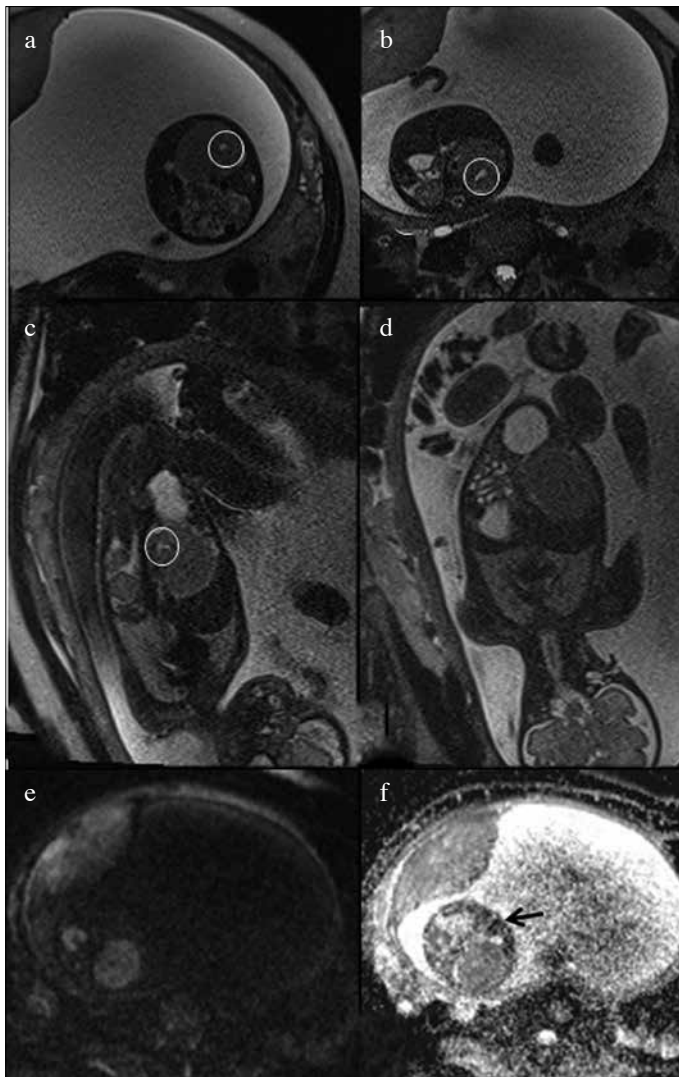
a-f. Fetal biparametric MR imaging in mesoblastic nephroma. T2-weighted images (a-d), diffusion-weighted images (e), and apparent diffusion coefficient map (f). Biparametric MR imaging shows an inhomogeneous iso-intense mass of the right kidney containing cystic lesions (O in a-c) on T2-weighted imaging, and areas of restriction of the water signal on apparent diffusion coefficient map (arrow in f).
